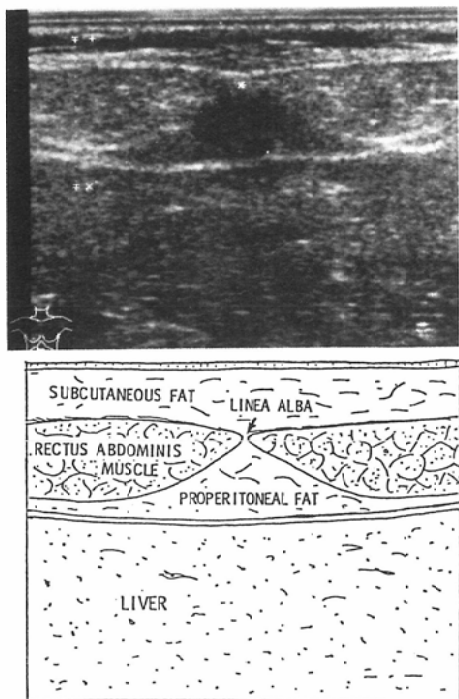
Transverse sonogram of the upper portion of the abdomen.
